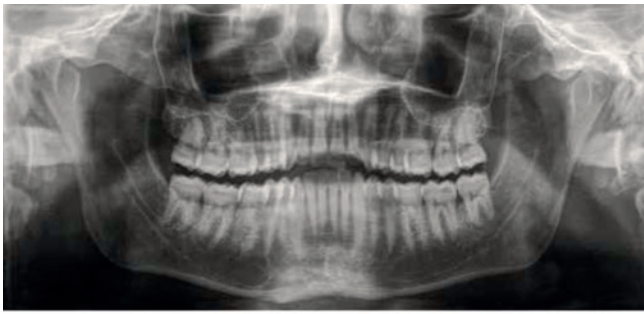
Panoramic x-ray and periapical x-ray series.
